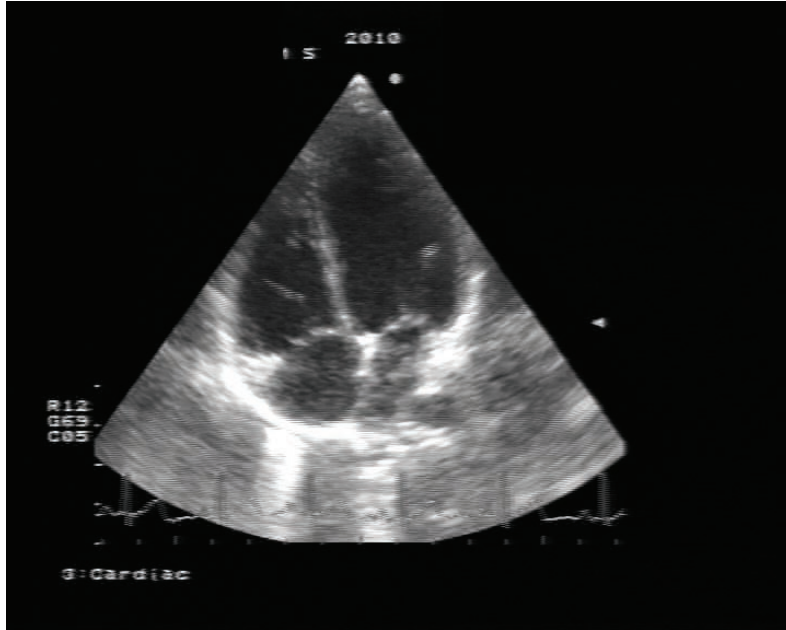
An example of an echocardiographic sectorial image.
